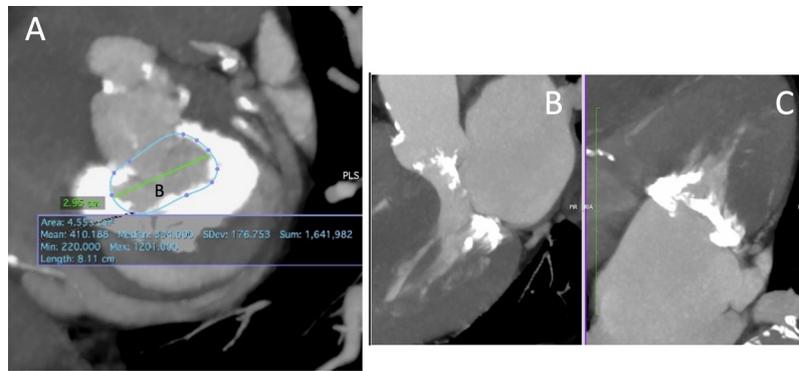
Pre-procedural cardiac computed tomography showing degree of mitral annular calcification.
